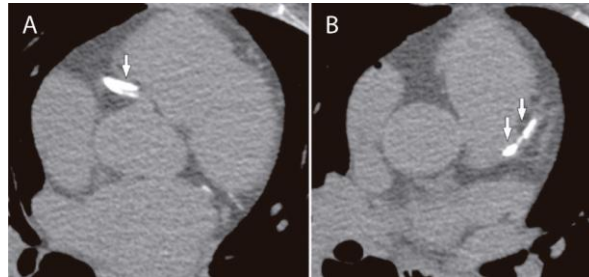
Computed tomography for calcium scoring scan (CaSc CT). Arrows indicate severe calcifications in the proximal right coronary artery (A), and left anterior descending artery (B). Adapted from Hamilton et al. [42].
